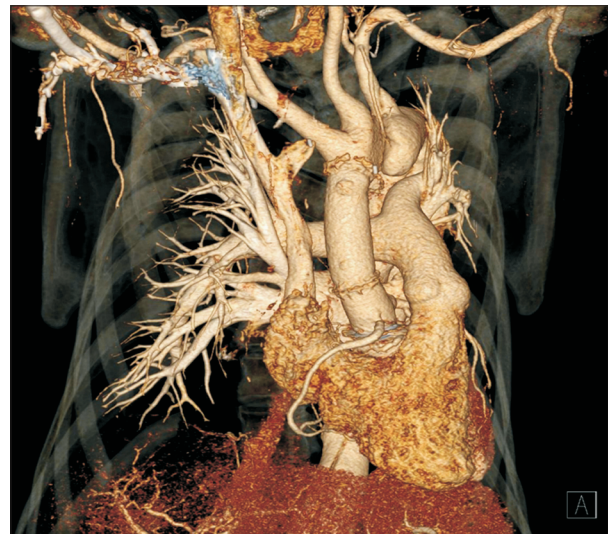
(A) Aneurysm of the coronary button (asterisk) and the left coronary artery (arrow). (B) Computed tomography angiography (3-dimensional reconstructed view) revealed a large (4.5 cm) aneurysm of the coronary button (asterisk) and combined anomalous origin of the right coronary artery from the left coronary sinus of Valsalva (arrow). (C) Stenotic right coronary ostium due to the proximal intramural course (arrowhead).
